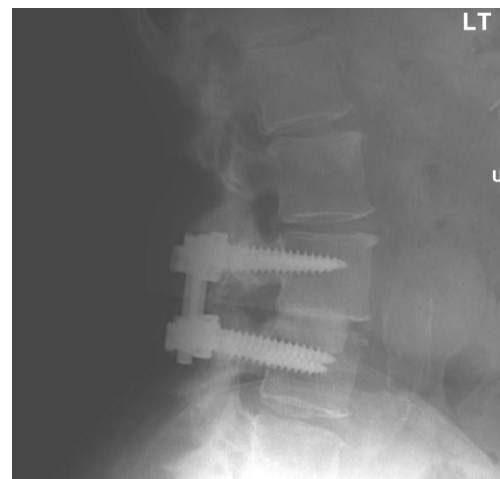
Lateral radiograph at 2 years post op
